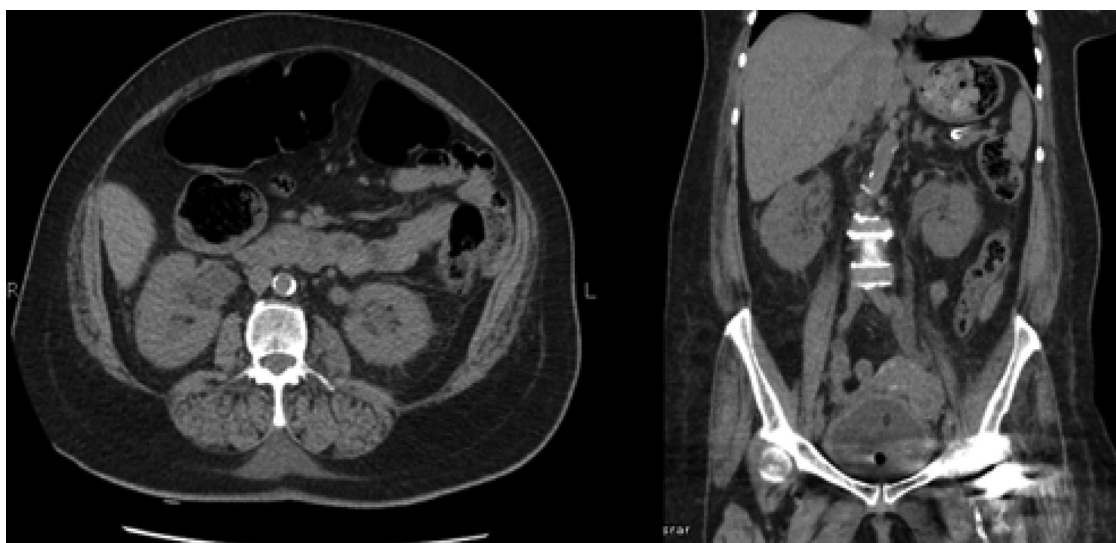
CT Abdomen showing Bilateral perinephric fat stranding with dilated ureters and bladder wall thickening suggestive of pyelonephritis.
